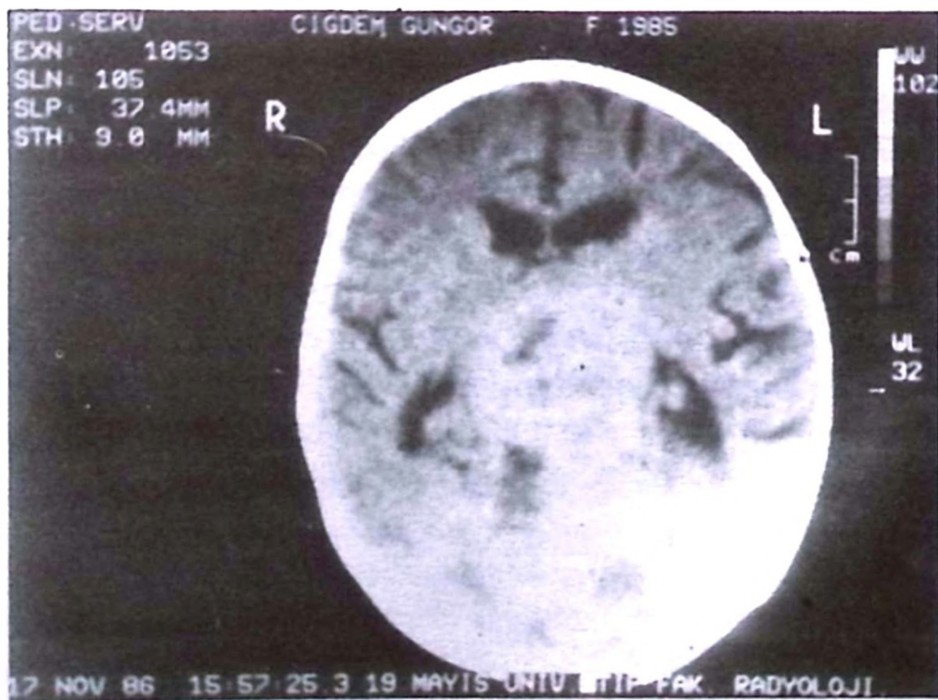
Precontrast CT study of Case No. 2 shows a conglomerate mass at the level of the tentorial hiatus extending to the cerebral convexity along the midline.
